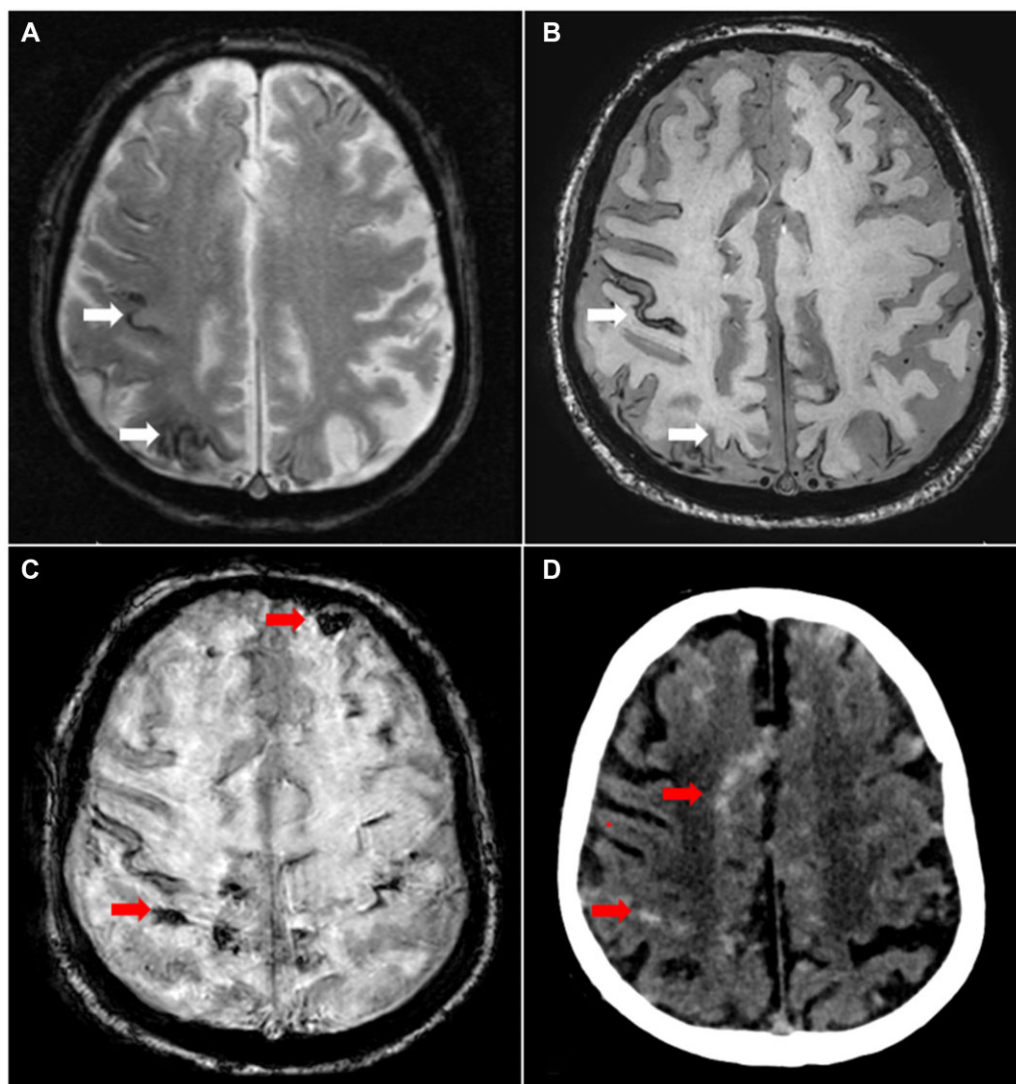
Radiological examination. (A) T2 sequence MRI performed after 1 year of follow-up. Cortical siderosis of the right convexity and occipital area (white arrows). (B) Overall stability of cortical siderosis (white arrows). (C) SWI sequence MRI performed 7 days before death. Frontal and parietal hyposignal corresponding to subarachnoid hemorrhage (red arrows). Artifacts are linked to the patient's movements. (D) CT scan with meningeal hyperdensity (red arrow) corresponding to subarachnoid hemorrhage.
